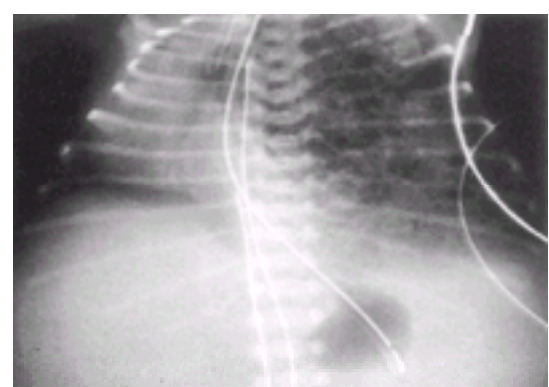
Chest radiograph in a newborn infant with cystic adenomatoid malformation of the left lung first identified on an antenatal ultrasound. It was a very large lesion producing a marked shift of the mediastinum to the right side. The infant developed severe respiratory distress in the delivery room requiring intubation and emergency surgical intervention. Despite resection of the mass the infant could not be adequately ventilated because of severe hypoplasia of the contralateral right lung as well as of the left lung. In this case the cystic adenomatoid malformation was so large that it produced bilateral pulmonary hypoplasia.
